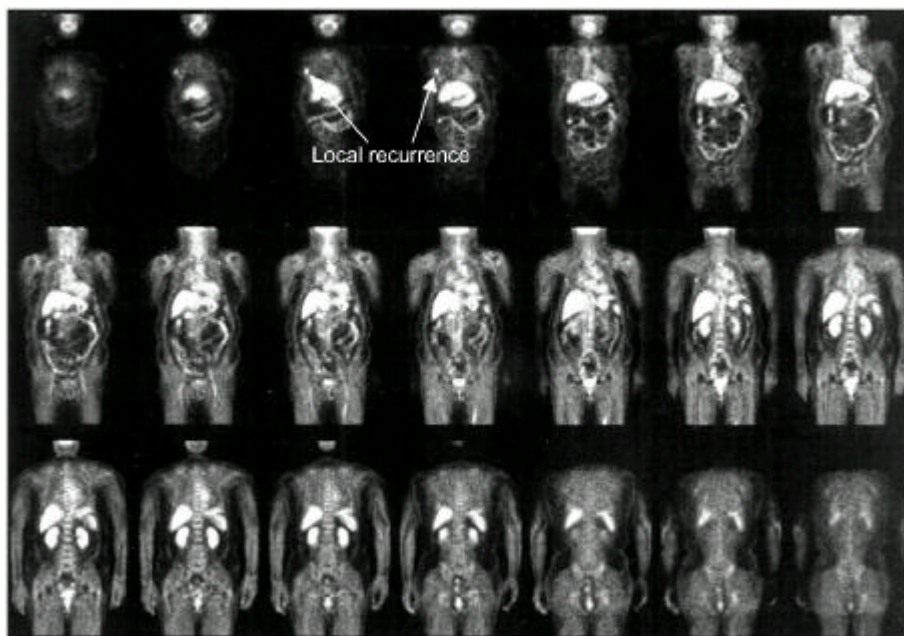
FDG-PET finding of local recurrence. A 56 year old female was operated modified radical mastectomy for right breast cancer with stage IIa at June, 1999. She was examined with PET at November, 2001 for a palpable nodule on her anterior chest. Anterior coronal FDG-PET cuts showed intense hypermetabolic foci (arrows), consistent with local recurrence and wide excision of a nodule on chest wall confirmed local recurrence of breast cancer.
